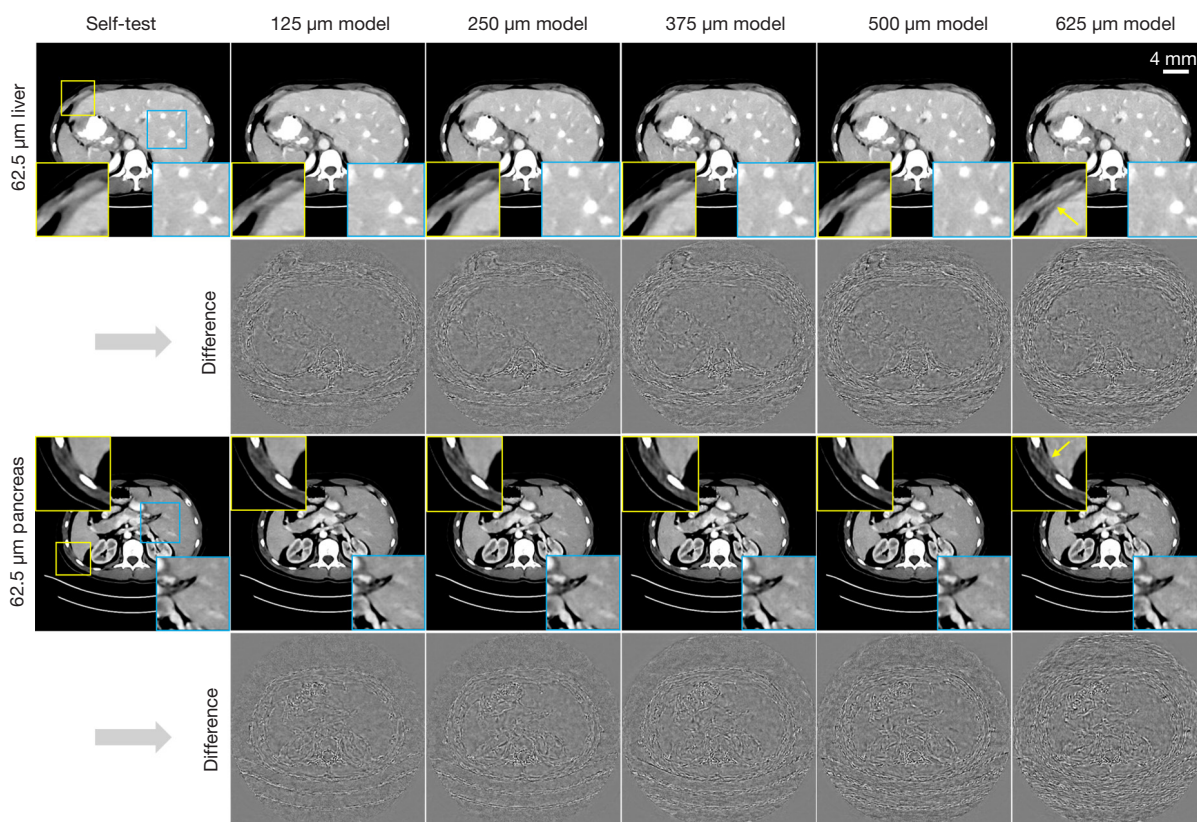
The U-Net test results of 62.5 μm CT images. The network test images are shown in the first and third rows, and the corresponding residual images which obtained by subtracting the self-test image from the cross-test images are shown in the second and fourth rows. The display window of test images is $[0.20, 0.24] \text{ cm}^{-1}$ and the display window of residual images is $[-0.007, 0.007] \text{ cm}^{-1}$. The scale-bars denote 4.0 mm. CT, computed tomography.
